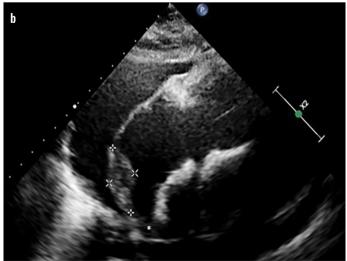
(a) Echocardiography in apical 4-chamber view showing right atrial mass, (b) Echocardiography in subcostal view with anterior tilt showing mass in right atrium and the superior vena cava (\*)
